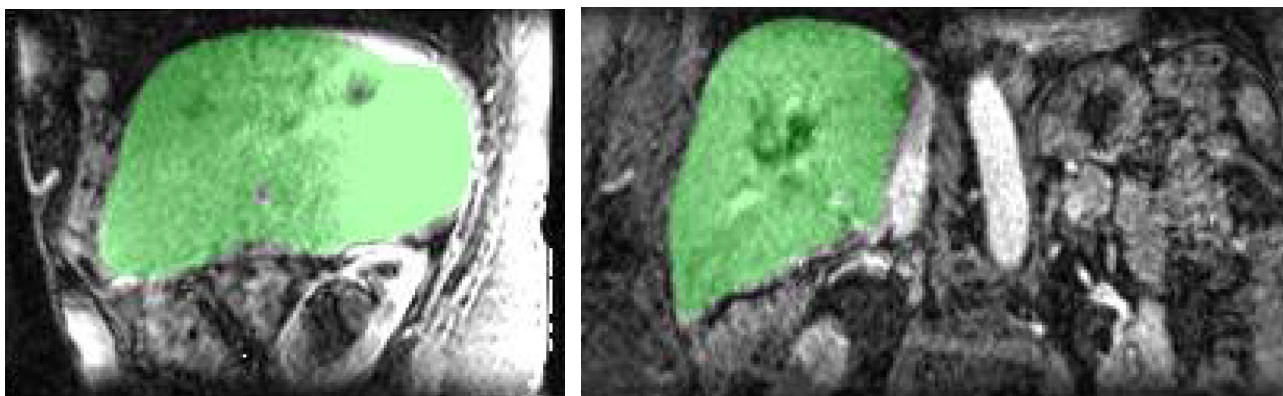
Sagittal and coronal slice of liver MRI with the TotalSegmentator prediction (green) overlapped.
